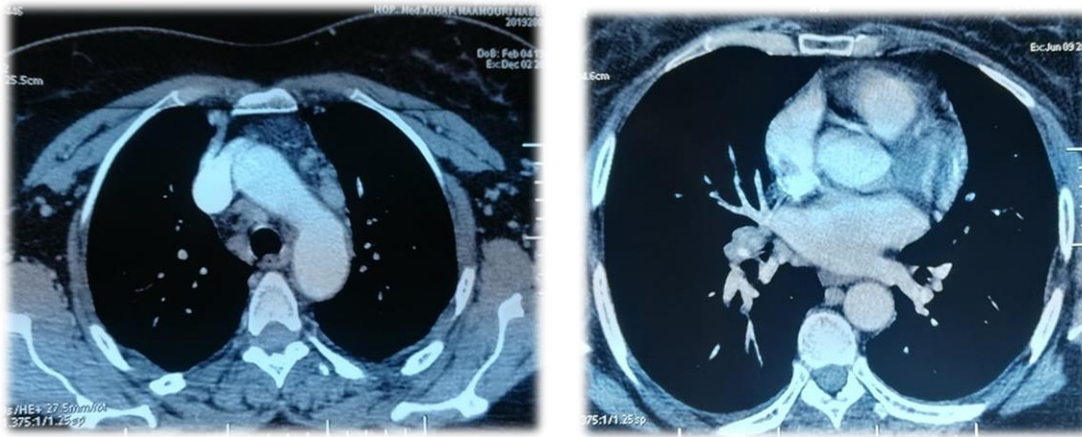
Axial CT images showing the aortic-pulmonary window and lateral-tracheal nodes
